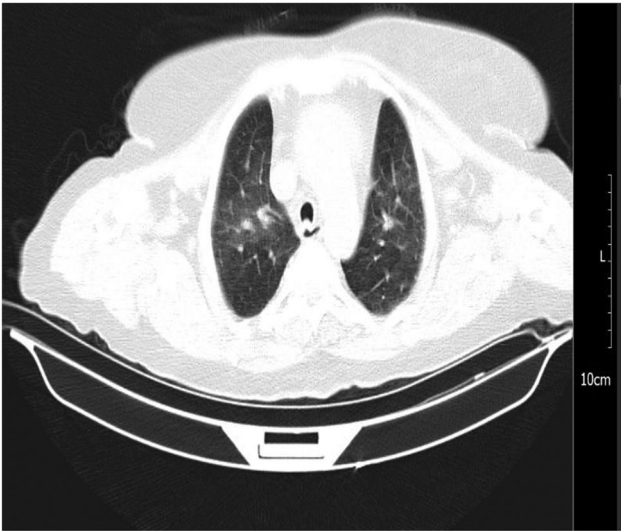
A chest computed tomography scan showed no parenchymal involvement in favor of COVID-19
